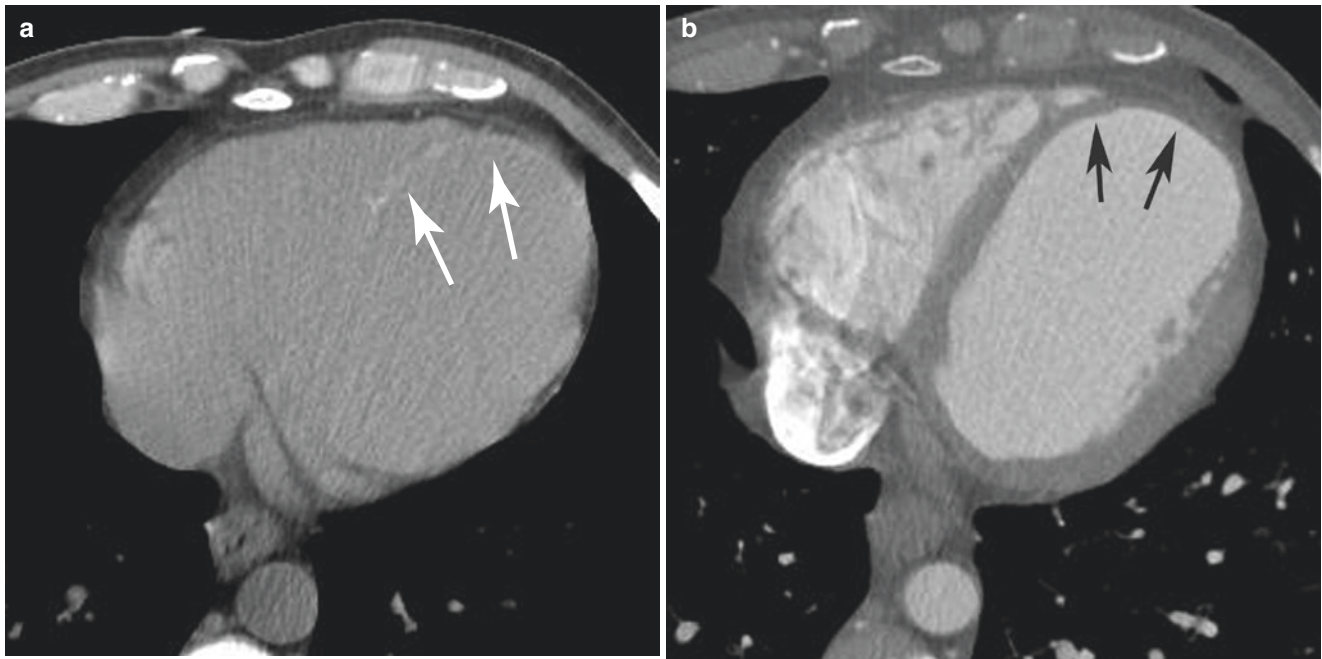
Dilated cardiomyopathy on non-gated cardiac CT
